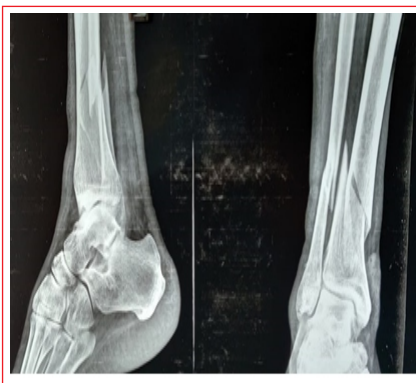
30 yr male, preoperative x-ray
